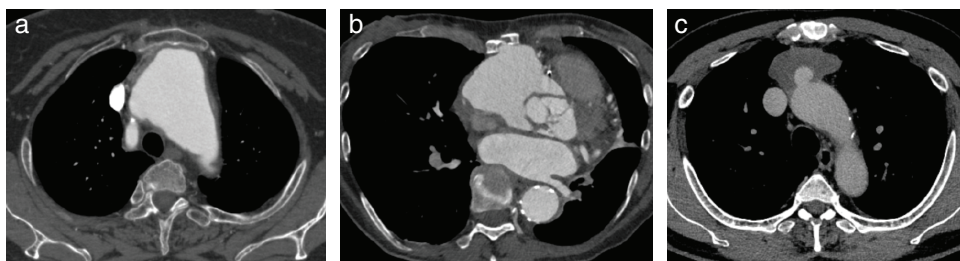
Preoperative computed tomography. (a) Case 3. Retro-sternal adhesion of the ascending aortic aneurysm is shown. (b) Case 4. Severe retro-sternal adhesion to the pseudoaneurysm is demonstrated. (c) Case 5. Close contact between the pseudoaneurysm and sternum is shown.
